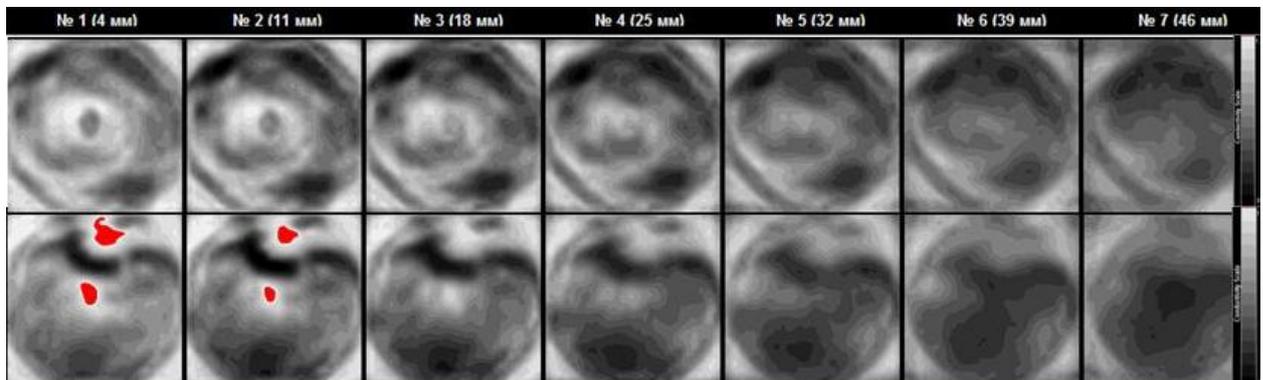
EIM. Top row – left gland. Age norm. Lower row – right gland. In the upper segment there is observed an an-impedance area, which is highlighted with red in two scan planes, with hyper-impedance contour, measured 27x27 mm. ULTRASOUND: In the upper-inner segment of the right gland there is observed an area *4 cm in size with moderate blood flow.
